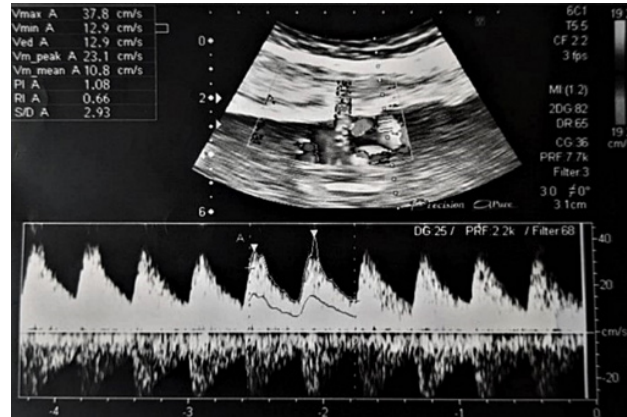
Spectral Doppler of the umbilical artery, obtained with pulsed-wave Doppler. The resultant peak systolic velocity (PSV) was 37.8 cm/s and resistive index (RI) was 0.66.
